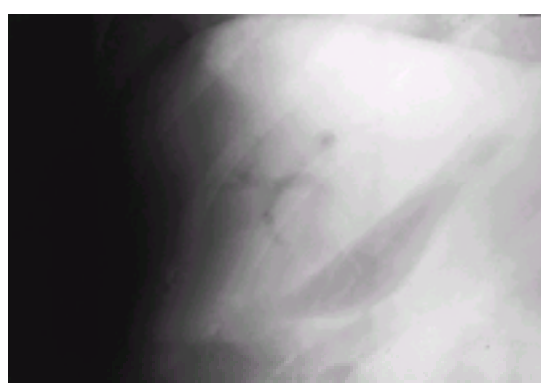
Air in the biliary tree on a plain radiograph.
